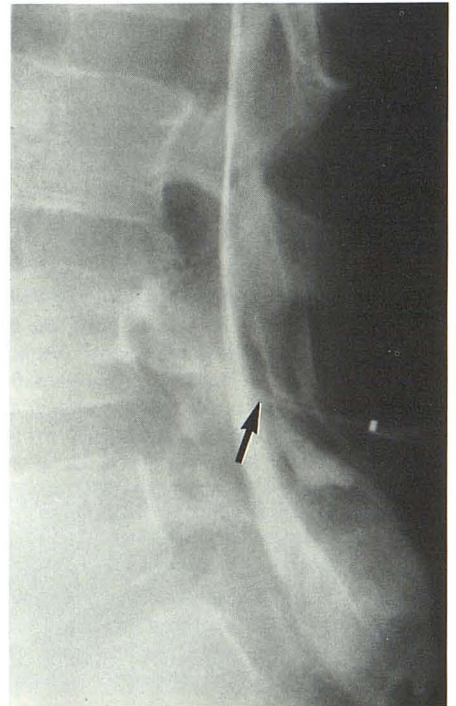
Lateral radiograph shows collapse of hydromyelic cavity. The myelotomy track (arrow) shows communication of hydromyelia and subarachnoid space.
